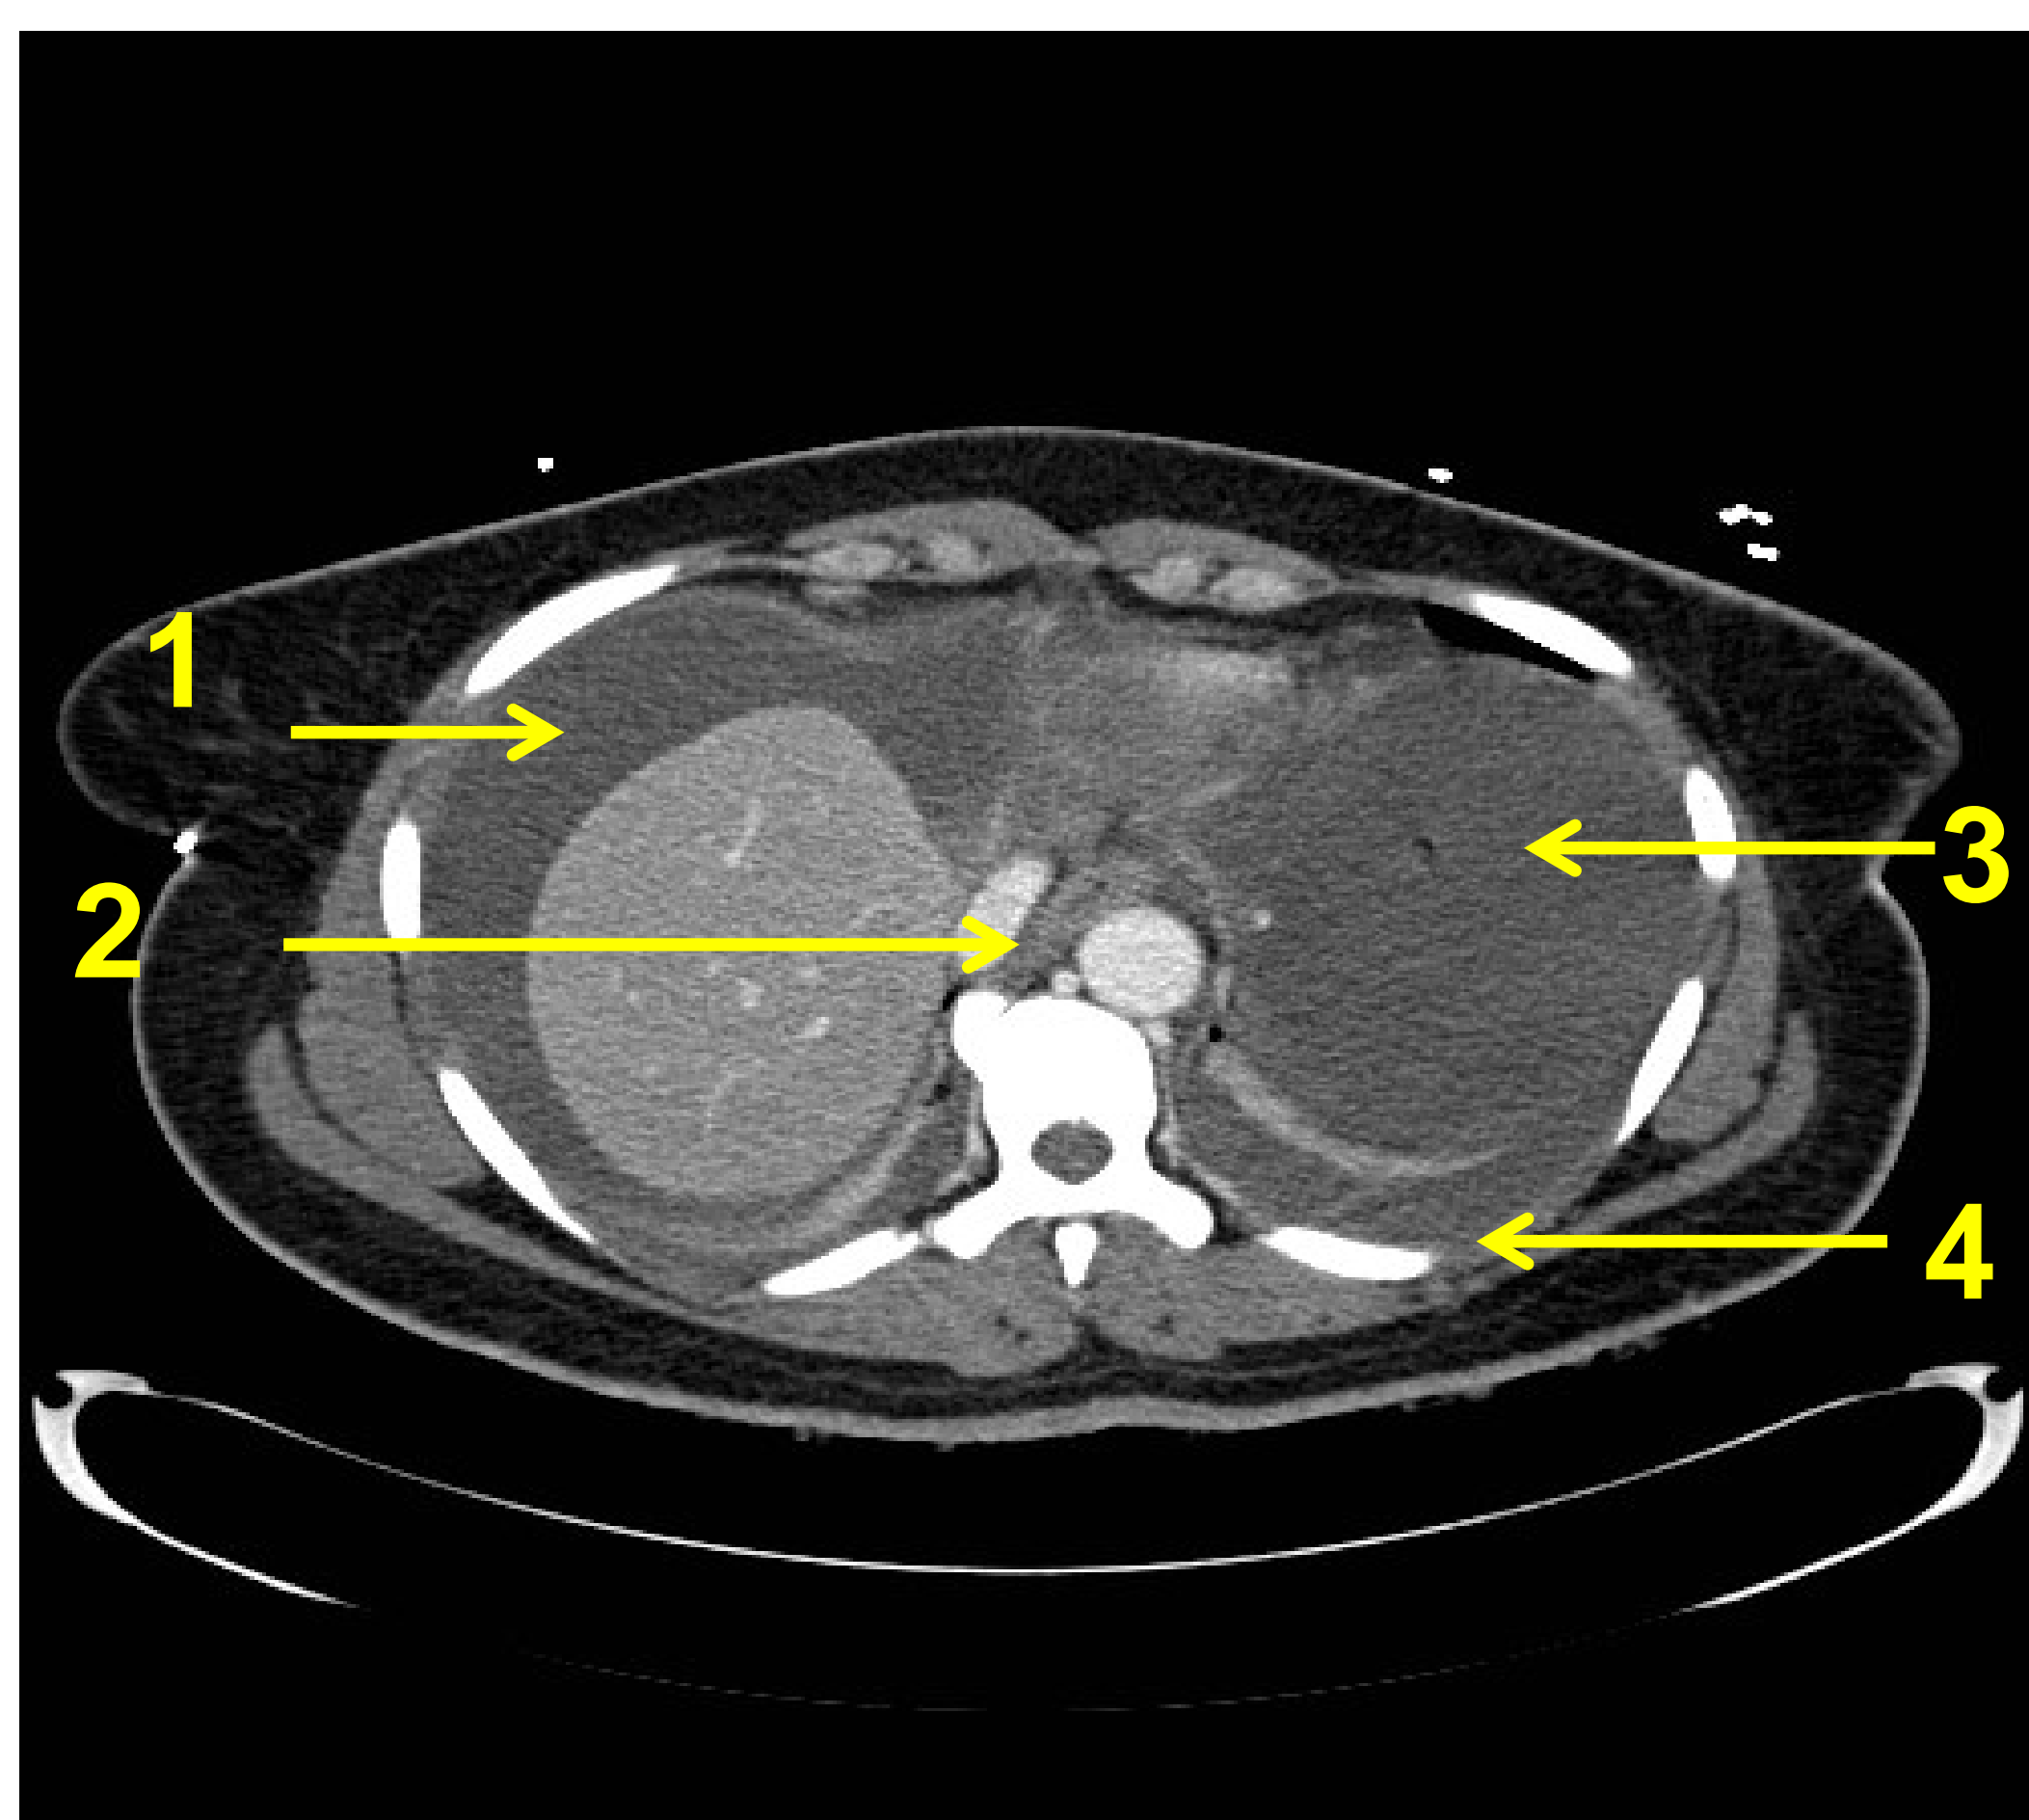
CT cross-section at level of oesophageal hiatus
